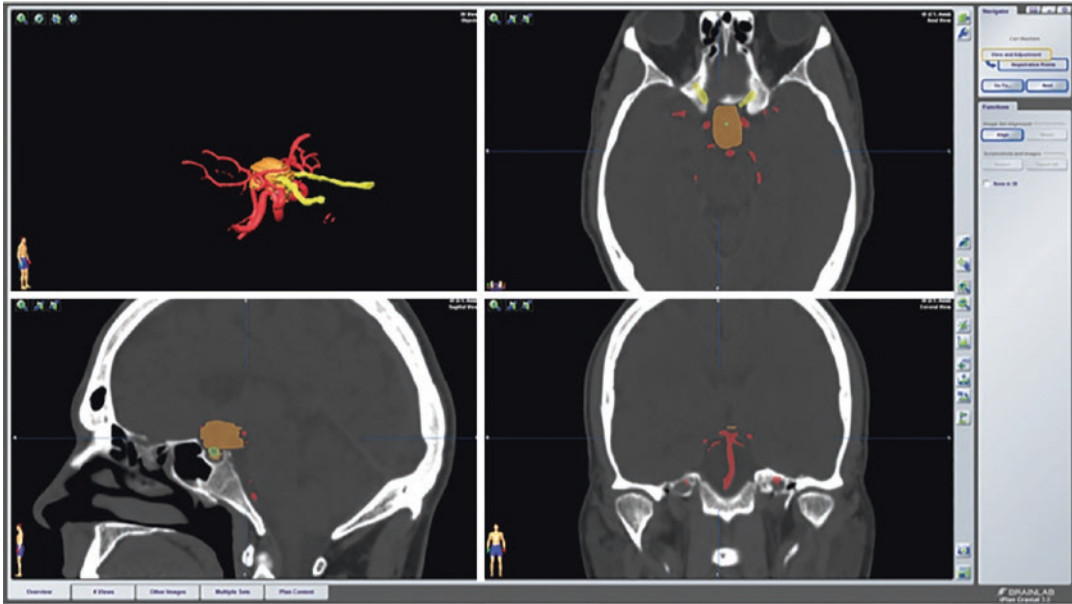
Screenshot of an image-guided system showing a pre-labelled craniopharyngioma (in orange) on axial images from a 3D-volumetric T1W MRI scan
